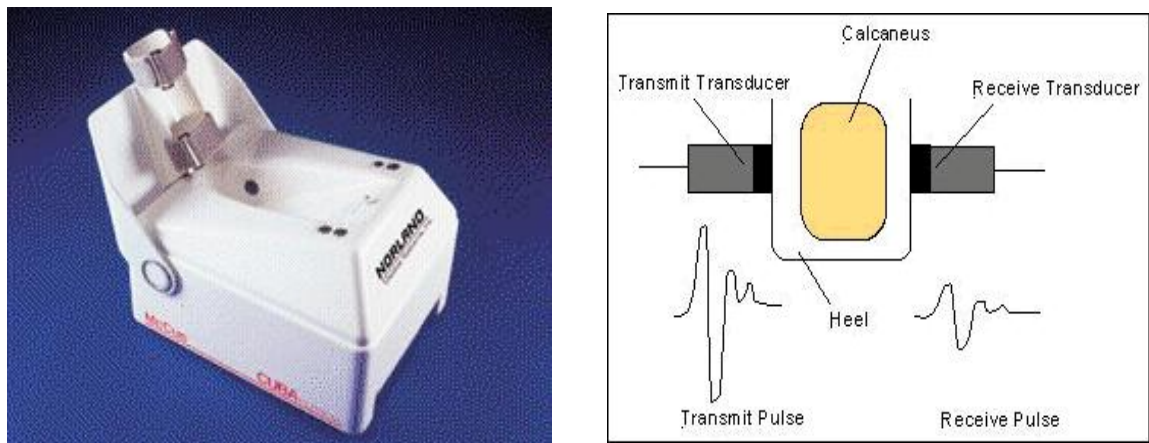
Calcaneal Ultrasound
